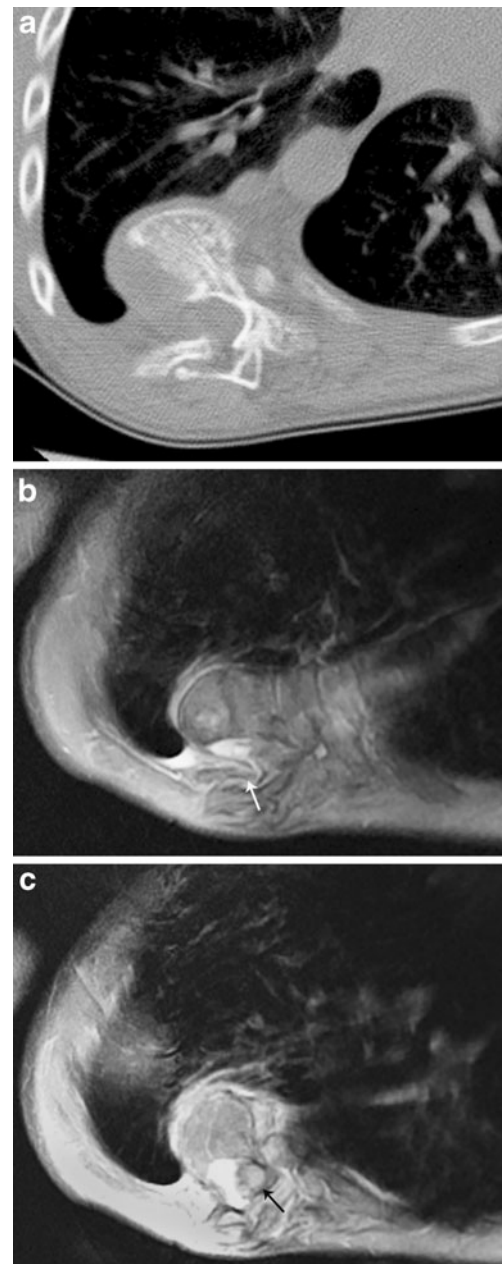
Case 3. a Axial CT demonstrates displacement of the right ninth rib head intraspinally. b, c Contiguous post-contrast axial T1-W MR images show the dislocated rib head (*white arrow*) with narrowing of the spinal canal but no cord compromise. The cord (*black arrow*) is located at the concave side of the curvature
